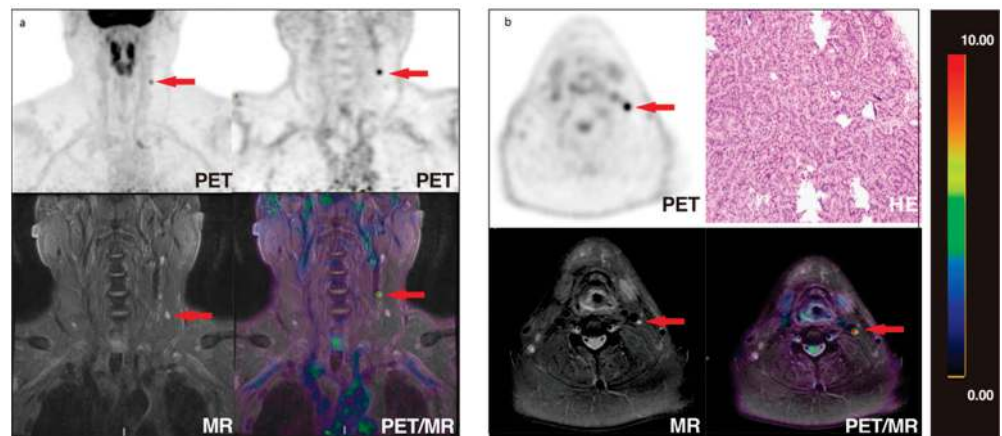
A 51-year-old DTC patient after comprehensive treatment presented with an unexplained increase in Tg (2.88 µg/L). PET/MR depicted an increased uptake of a small lymph node (long diameter, 0.7 cm) in the left level III, with SUVmax 5.1, without other apparently abnormal lymph nodes ((a,b), red arrows). 30 suspicious lymph nodes were removed by re-operation, and notably, only the lymph node identified on PET/MR was malignant.
